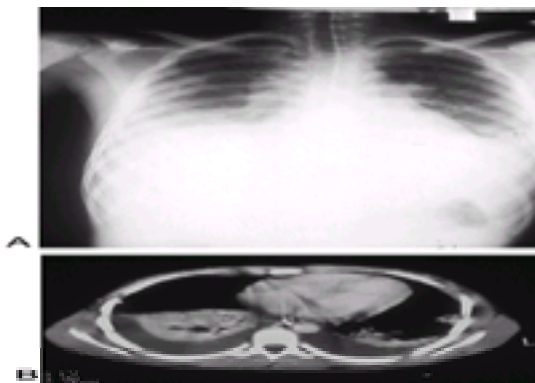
A 15-year-old child involved in an auto–pedestrian accident. Vital signs were stable at the scene, but the child had decreased breath sounds bilaterally. (A) Chest radiograph showed bilateral hemothorax and pulmonary contusions. (B) Computed tomography confirmed and better delineated the hemothorax and pulmonary contusions.
